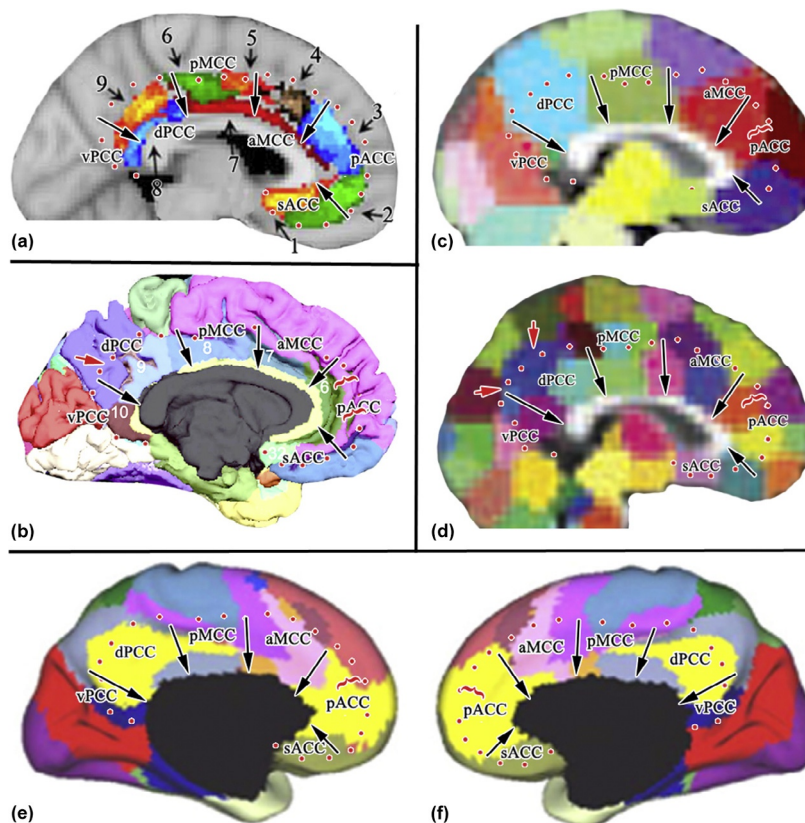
Medial surfaces from MRI studies. In all instances, the subregional borders are marked with arrows, and the external edge of the cingulate cortex is marked with red dots. Red arrows in (b) and (d) emphasize mismatches between the boundary of cingulate cortex and the maps, and red parentheses emphasize where area 32 should be located in the maps. (a) Beckmann et al. (2009), (b) Destrieux, Fischl, Dale, and Halgren (2010), (c, d) Craddock, James, Holtzheimer, Hu, and Mayberg (2012) for 50 and 1000 specified ROIs, respectively, (e) left and (f) right hemispheres from Yeo, Krienen, Sepulcre, et al. (2011).
